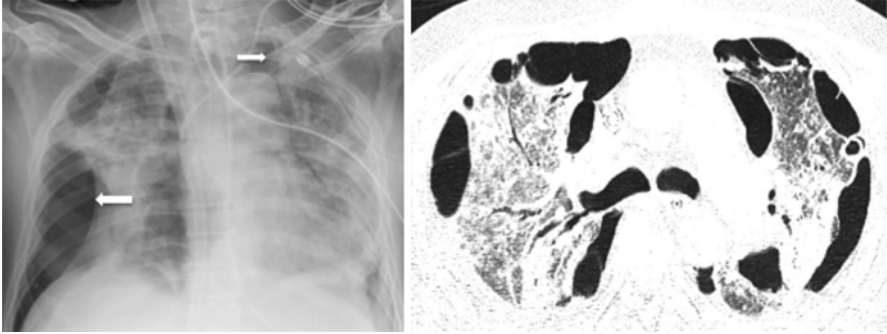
CXR and a selected HRCT image to show parenchymal changes of ARDS. Also note the left pneumothorax (*thin arrow*) with multiple adhesions and surgical emphysema. Note also the well defined lung edge with no lung markings lateral to it in keeping with loculated pneumothorax (*block arrow*)
